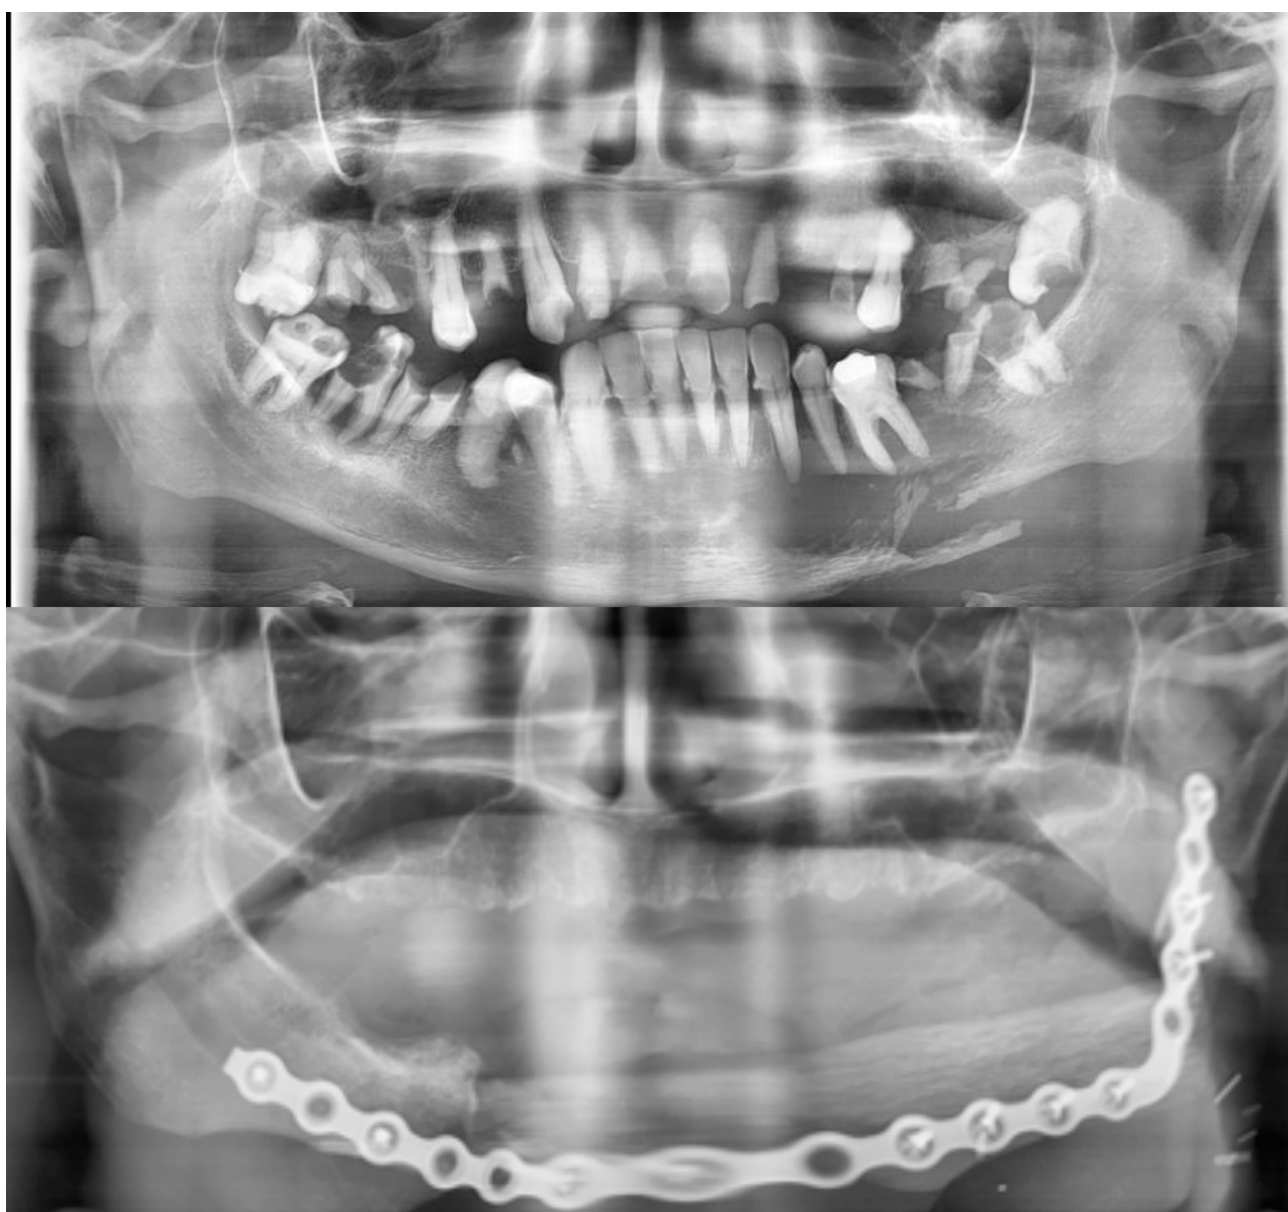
Orthopantomogram before chemotherapy treatment (a). Showing pathological fracture with poor dental status. Orthopantomogram after surgery (b). Showing a fibular free flap with a reconstruction plate in place.
